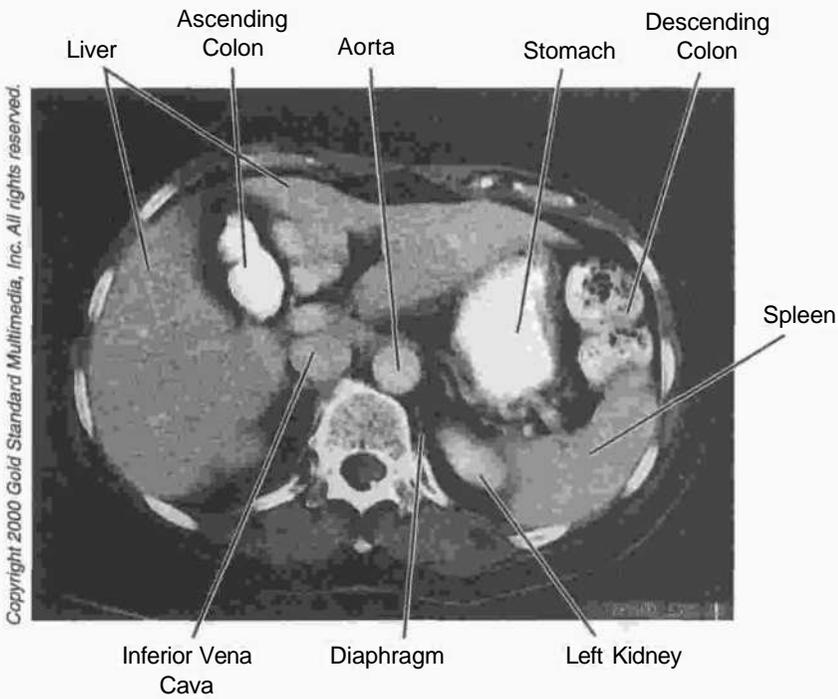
Figure Ili-3-39. Abdomen: CT, T₁₂
